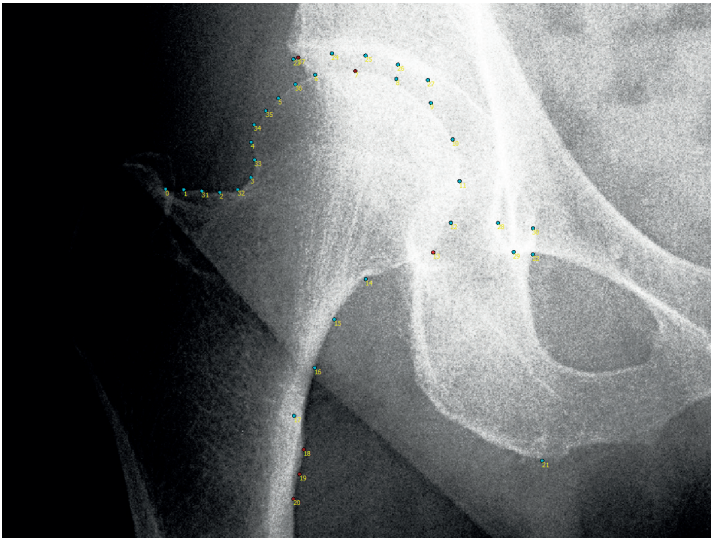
Example of the landmark points with point indices on a right hip of a pelvic radiograph.
